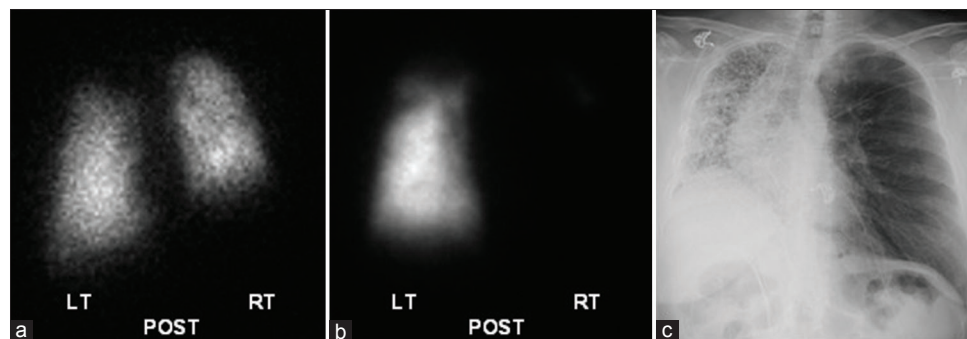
Pulmonary fibrosis with left lung transplant. (a) Ventilation image showing a small right lung and symmetrical ventilation. (b) Perfusion image showing no perfusion to the native right lung. (c) Chest radiograph showing fibrosis throughout the native right lung and a clear transplanted left lung. LT indicates left; POST: Posterior; RT: Right
